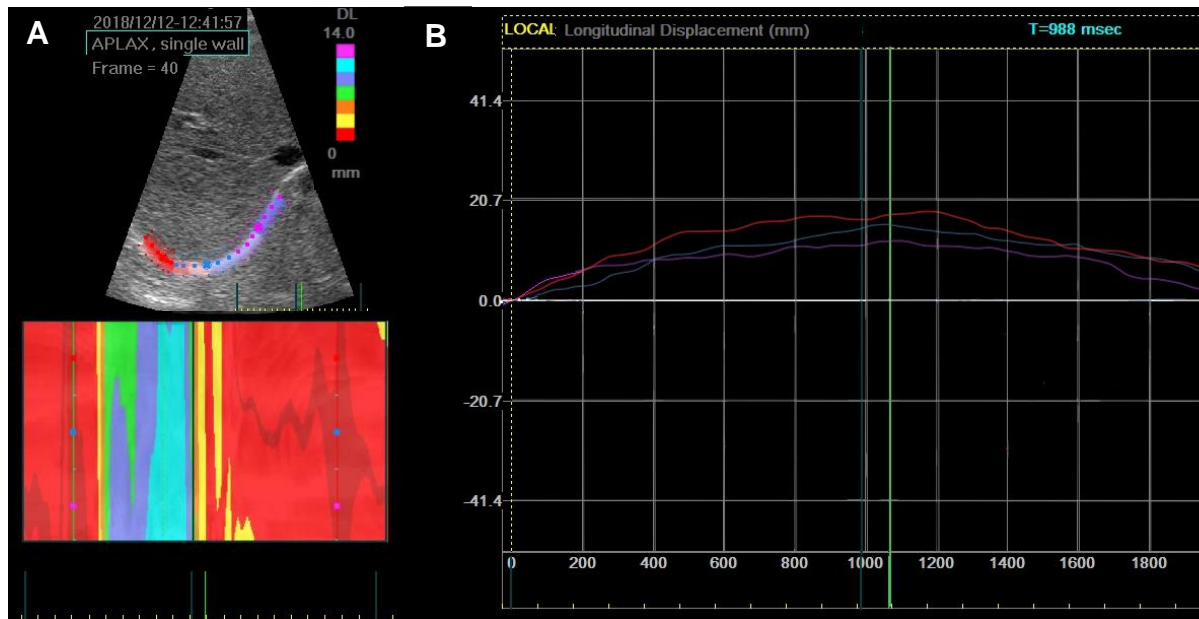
Speckle-tracking analysis of diaphragm excursion (‘displacement’) during a respiratory cycle. *A*) The region of interest (ROI) was drawn on the B-mode ultrasound and automatically divided into three sub-regions, distinguished by colours red, blue and pink. *B*) Diaphragm excursion expressed time-motion capture, with the ordinate representing excursion (mm) and the abscissa as time (ms). In this example, the excursion of crural diaphragm apex (blue sub-region) was 1.87 cm with an excursion time of 1.06 s in a female participant during quiet breathing.
